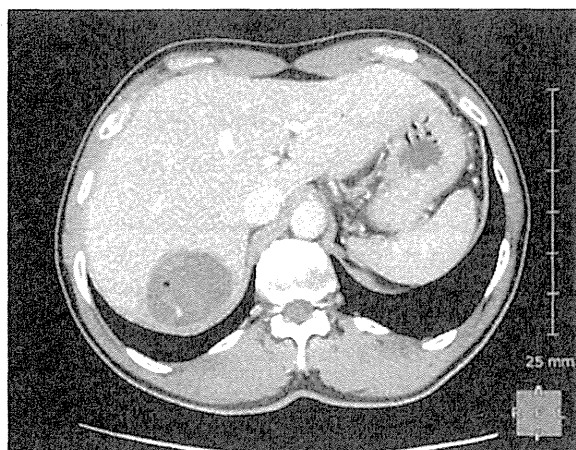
Preoperative abdominal CT. The metastatic melanoma was located in S7. There were no other tumors in the liver or other organs.
